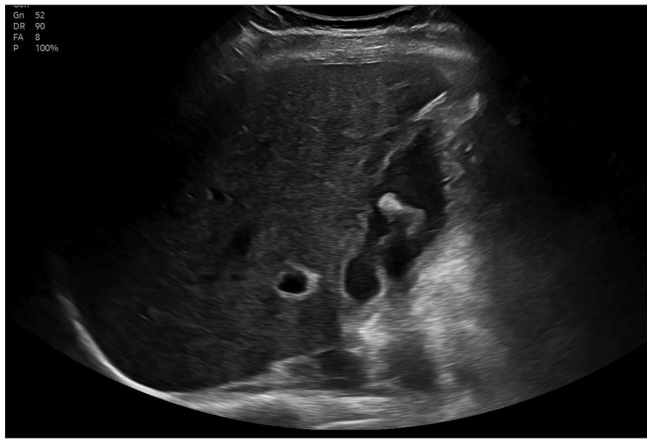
Grayscale ultrasound image of the liver and gallbladder
